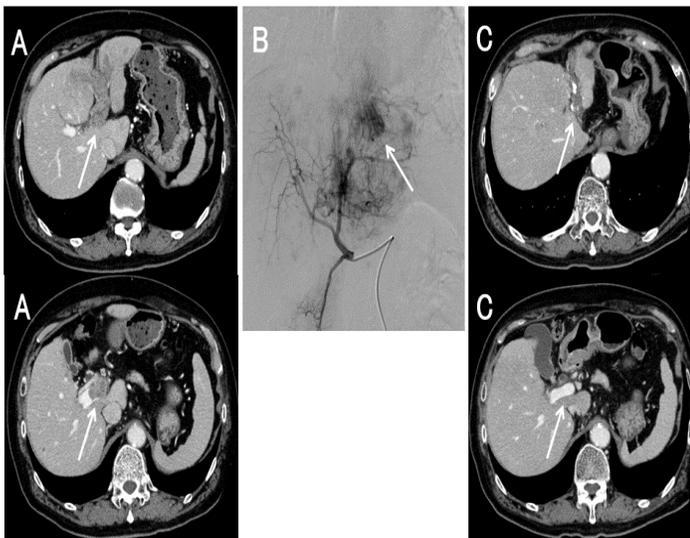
A representative case: enhanced CT of pre- and post-treatment and angiography of pre-treatment of CR case. This patient has survived for 4.7 years.
